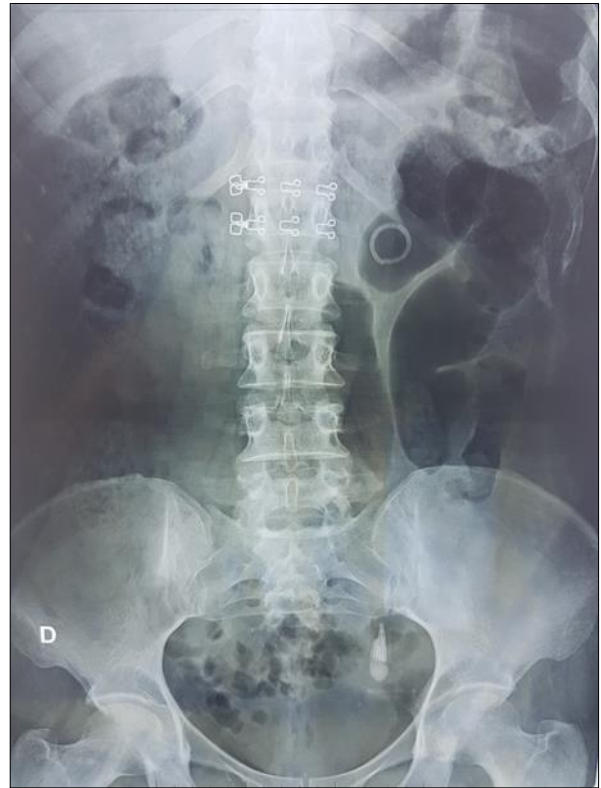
Abdominal radiograph showing a ruptured double J tube
